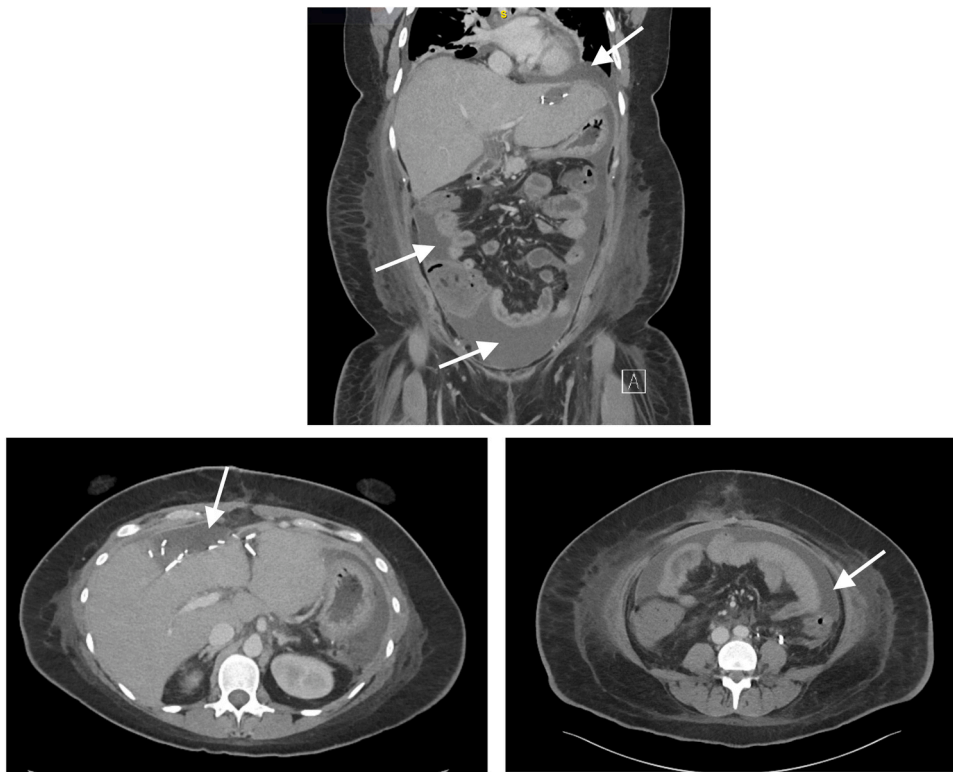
CT scans showing abdominal ascites (white arrows), with a large fluid collection in the left upper quadrant surrounding the stomach and anterior pelvis (coronal plane, upper; axial plane lower right) in addition to an anterior loculated perihepatic fluid collection (axial plane, lower left).
